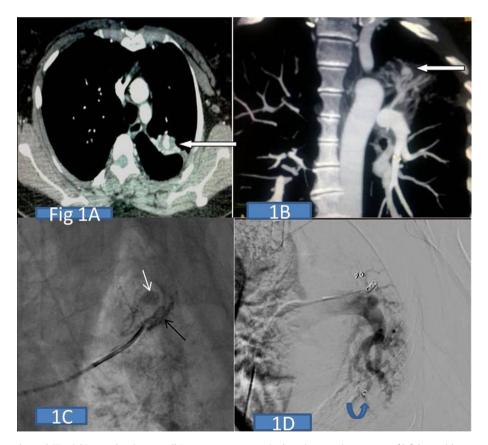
A. Contrast enhanced CT axial image showing a small Rasmussen aneurysm in the apicoposterior segment of left lung with surrounding cavity with hypervascular wall (arrow). B. coronal MIP image showing the aneurysm in relation to left upper lobe segmental branches. C. DSA shows catheter in left upper lobe segmental branch with filling up of aneurysm (white arrow) and contrast blush (black arrow) in the surrounding lung. D. DSA post coil embolisation in the subsegmental branches of left upper lobe showing no filling of aneurysm and the absence of hypervascularity and blush in the surrounding lung. One of the coils (curved arrow) has accidently migrated into one of the segmental branch of left descending pulmonary artery.
